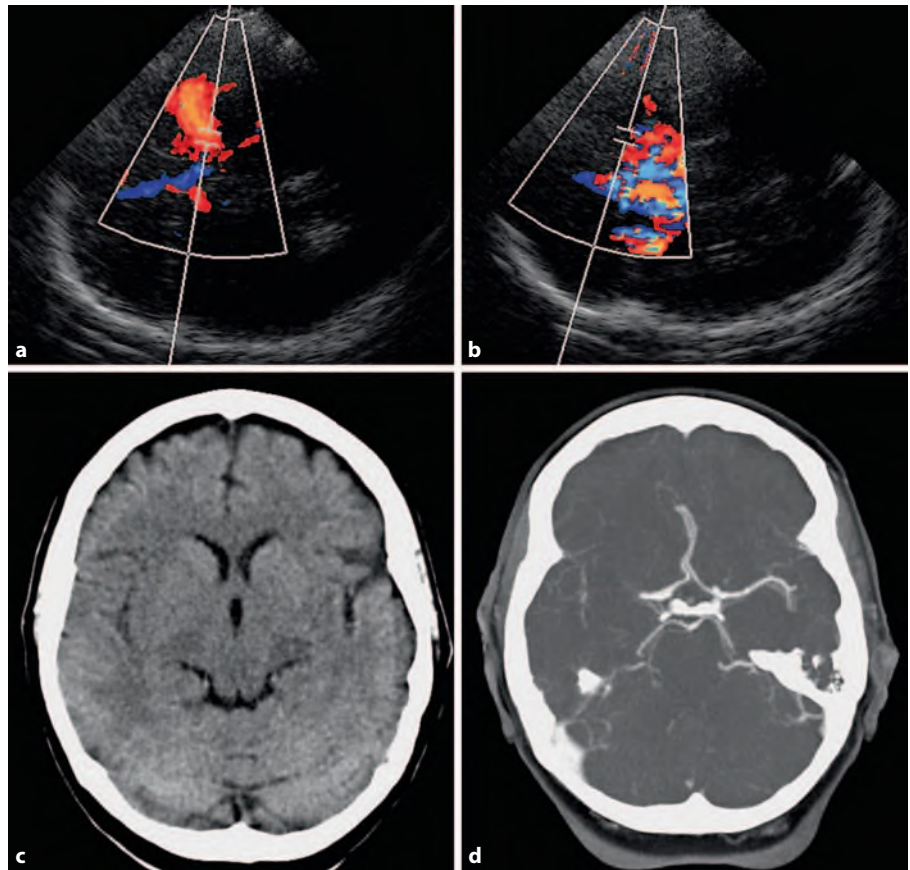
Images obtained in a 57-year-old patient with acute left-sided hemiparesis and right-sided gaze. a, b Contrast-enhanced TCCS images showing a patent left MCA 25 min after symptom onset (a) and proximal occlusion of the right MCA (b), which is consistent with the patient's stroke symptoms. c Cerebral CT scan obtained 65 min after symptom onset exhibiting mild hypointensities of the right basal ganglia. d CTA confirming right MCA occlusion. (To compare to panel b, rotate 90° counterclockwise.)
